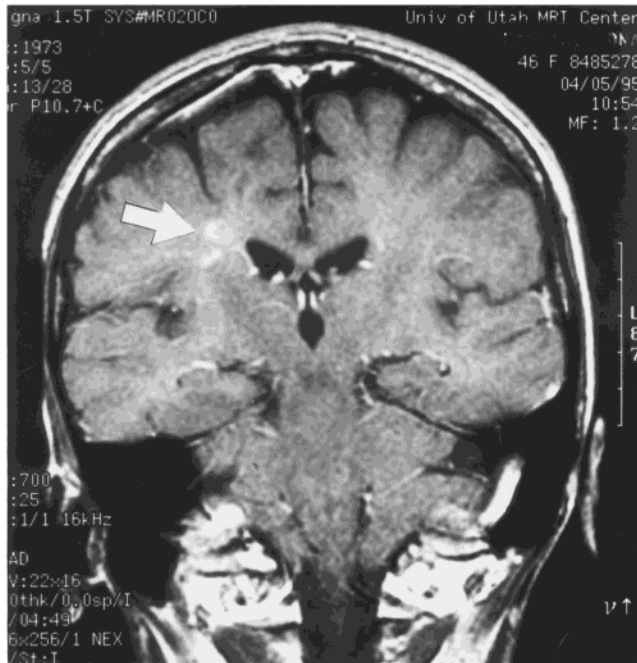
Coronal MRI prior to BMT showing gadolinium enhancing periventricular lesions (TR 700, TE 25). Gadolinium enhancement represents abnormally increased permeability of the blood-brain barrier and correlates with disease activity in multiple sclerosis.
